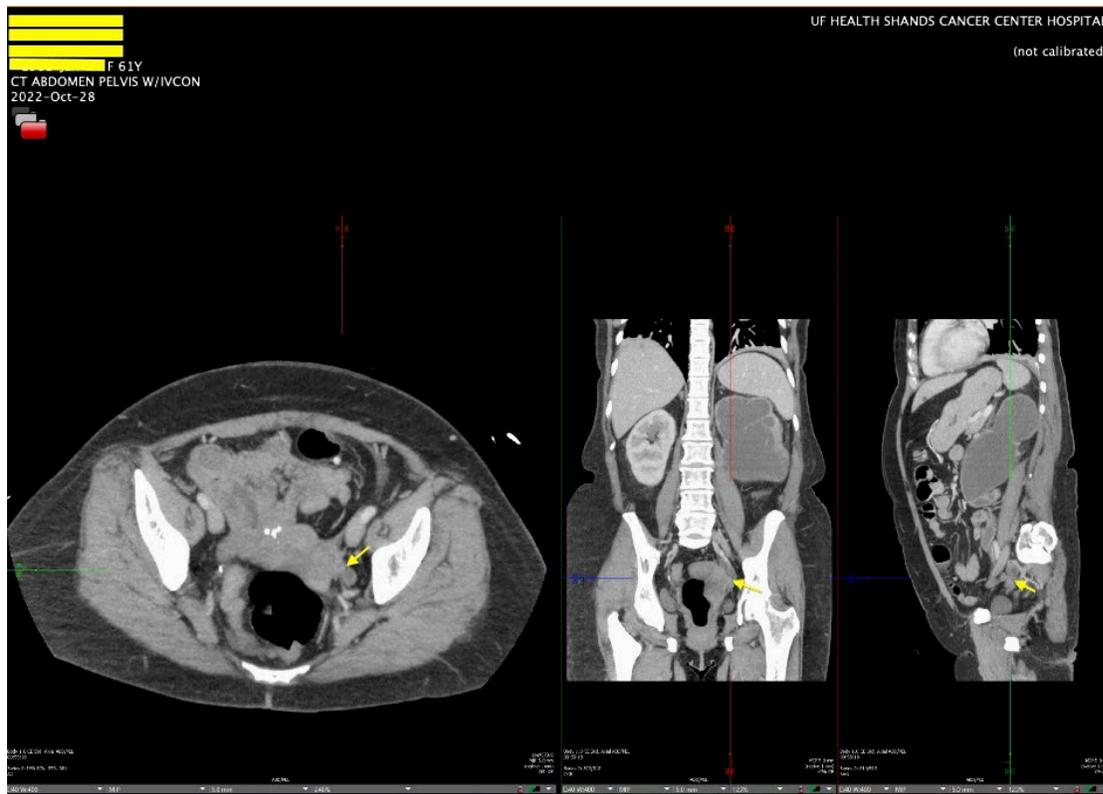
CT Abdomen Pelvis with left hydroureter and chronic atrophy of ipsilateral kidney
